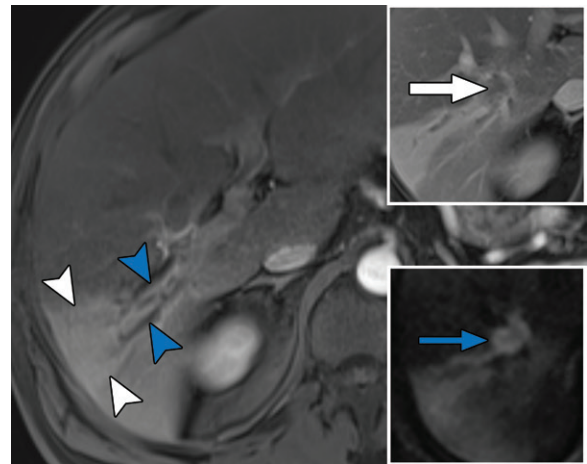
THID from a hepatic metastasis in a 39-year-old man with metastatic colorectal cancer. Axial T1-weighted arterial phase MR image shows THID (white arrowheads) in the right posterior section and peripheral biliary ductal dilatation (blue arrowheads). T1-weighted portal venous phase MR image (top inset) shows a central hypoenhancing liver metastasis (white arrow) as the cause of biliary obstruction and resultant THID. Diffusion-weighted image (bottom inset) helps identify the metastasis (blue arrow), which may otherwise be obscured by adjacent THID.
